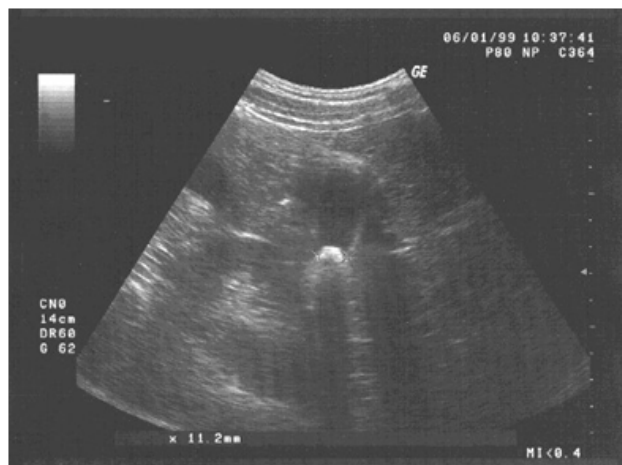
Final ultrasound examination of the gallbladder patient.
